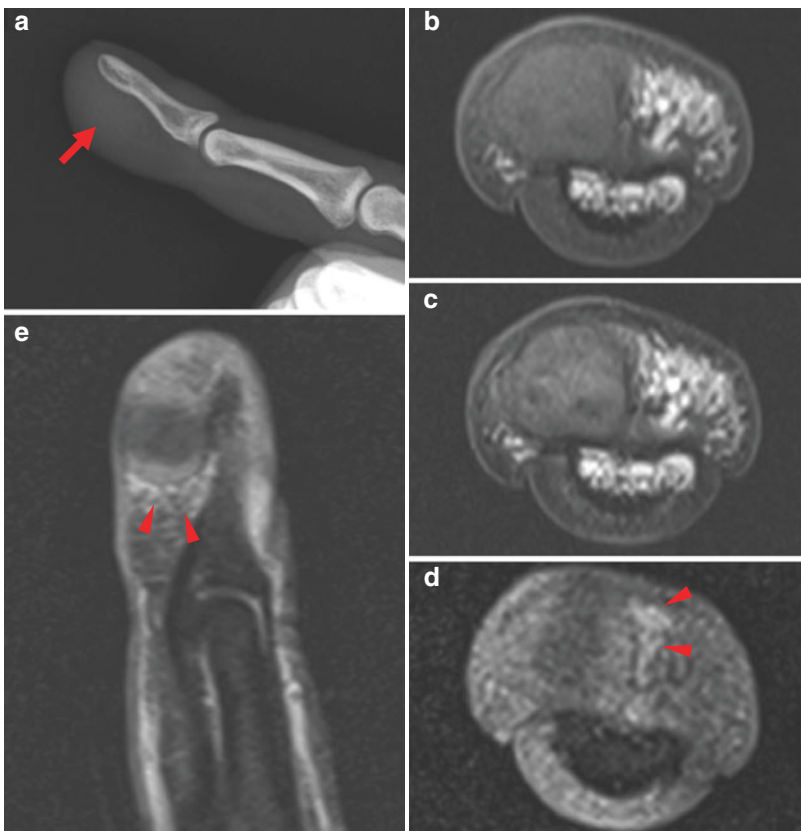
Deep benign fibrous histiocytoma. Lateral radiograph (a) reveals a nonspecific soft tissue mass (arrow) along the palmar aspect of the distal phalanx. There is no osseous involvement. This well-circumscribed subcutaneous mass is isointense to slightly hyperintense
